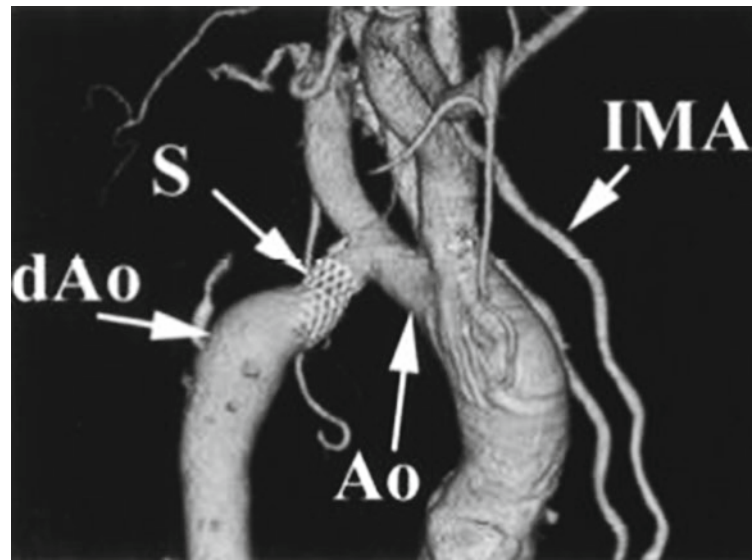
A 64-slice CT angiogram of an adult with coarctation of the aorta following endovascular stent deployment. (a) An axial cut at the level of the proximal descending thoracic aorta demonstrates a widely patent, well-apposed 14-mm bare-metal uncovered stent (S)
